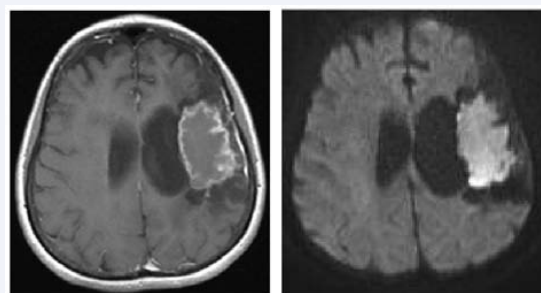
Further MR imaging of the brain demonstrates an irregular lesion within the area of left encephalomalacia which, on post-contrast T1 sequences, shows a thin rim of peripheral enhancement (A) and homogenous diffusion-restriction on DWI sequencing (B).
